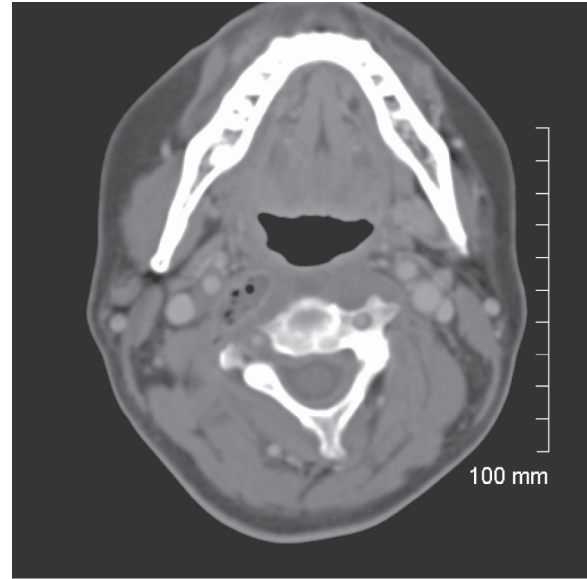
Axial CT scan image demonstrating right sided retropharyngeal abscess.
